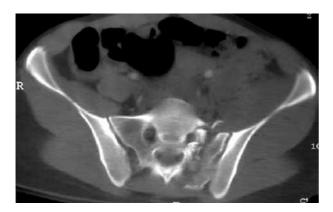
Pelvic CT scan showing left displaced transforaminal sacral fracture.
